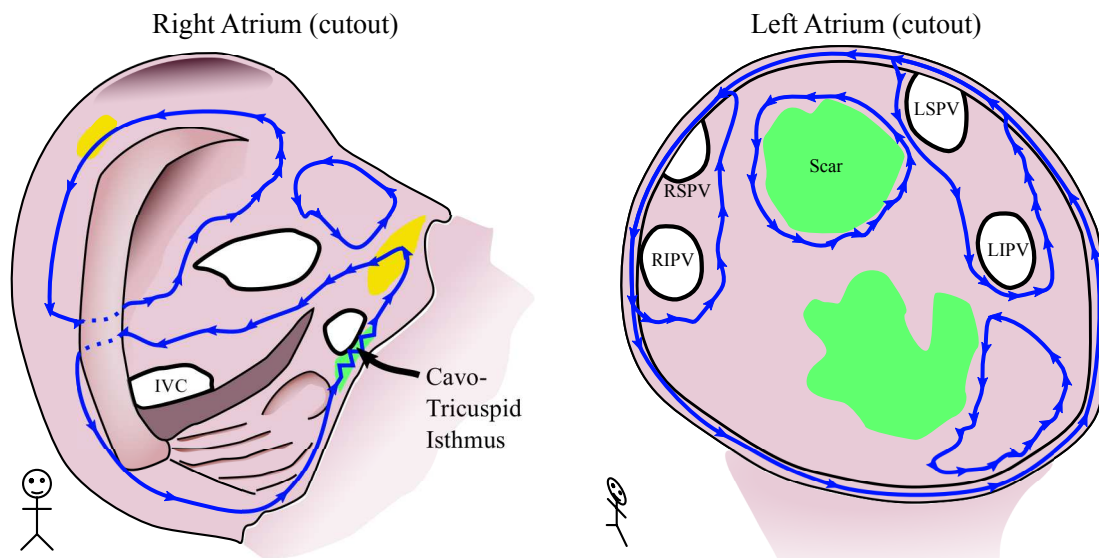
Examples of atypical flutter circuit in the right and left atrium. Dotted lines indicate CT breakthrough: abnormally fast conduction in the transverse direction to the cardiac fibers.
